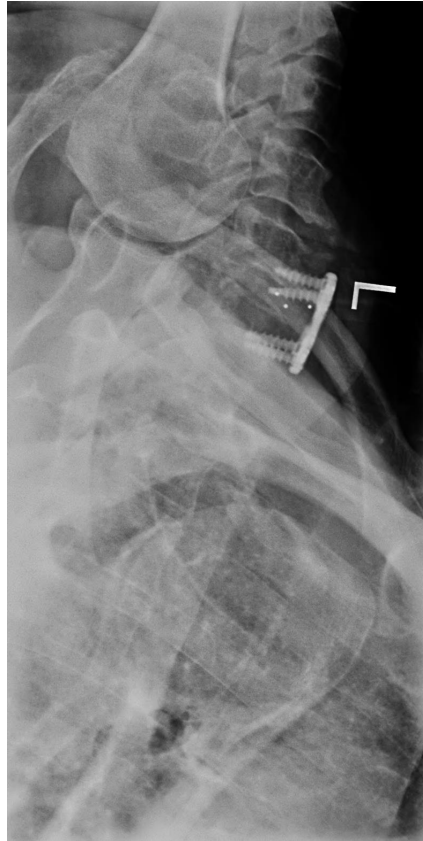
Postoperative oblique view radiograph highlighting C6-C7 ACDF.
